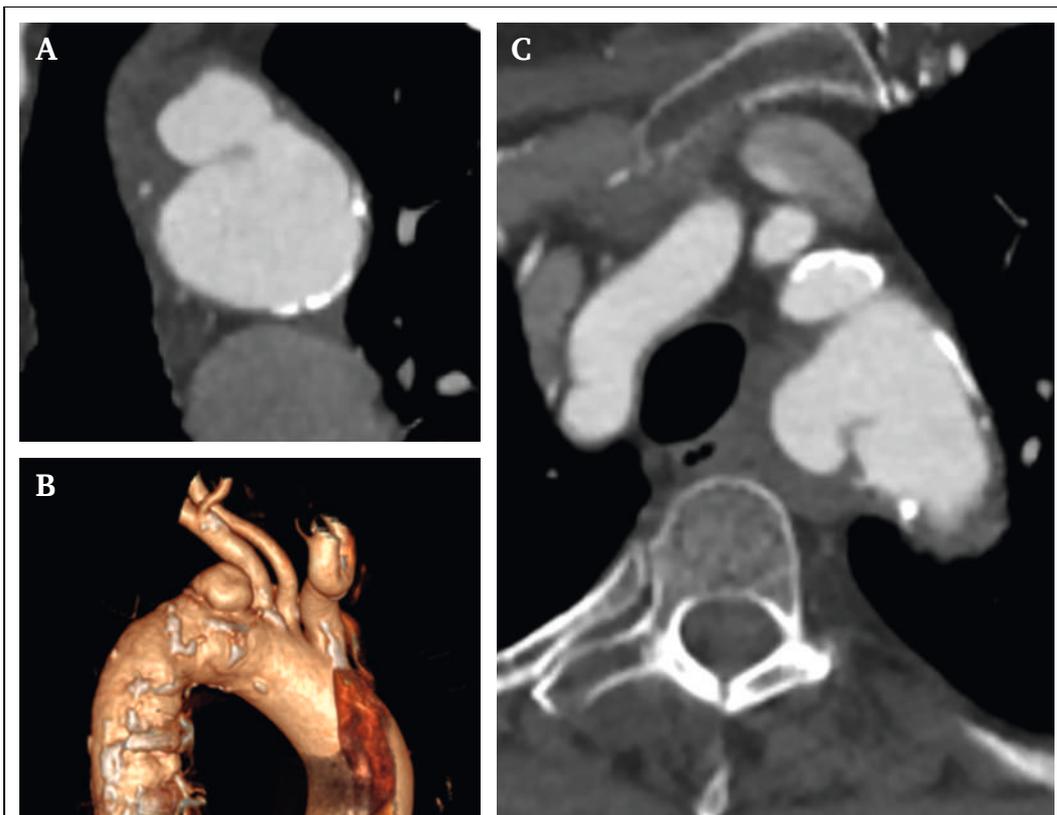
Penetrating aortic ulcer of the proximal descending aorta. (A) Computed tomography angiography (CTA) in coronary-style projection, (B) 3D volume-rendered reconstruction highlighting the morphology and extent of the penetrating aortic ulcer (PAU), (C) Axial CTA image at the level of the supra-aortic trunk origins, showing the precise location of the PAU. (artist and copyright Carlota F. Prendes, Uppsala, Sweden).
